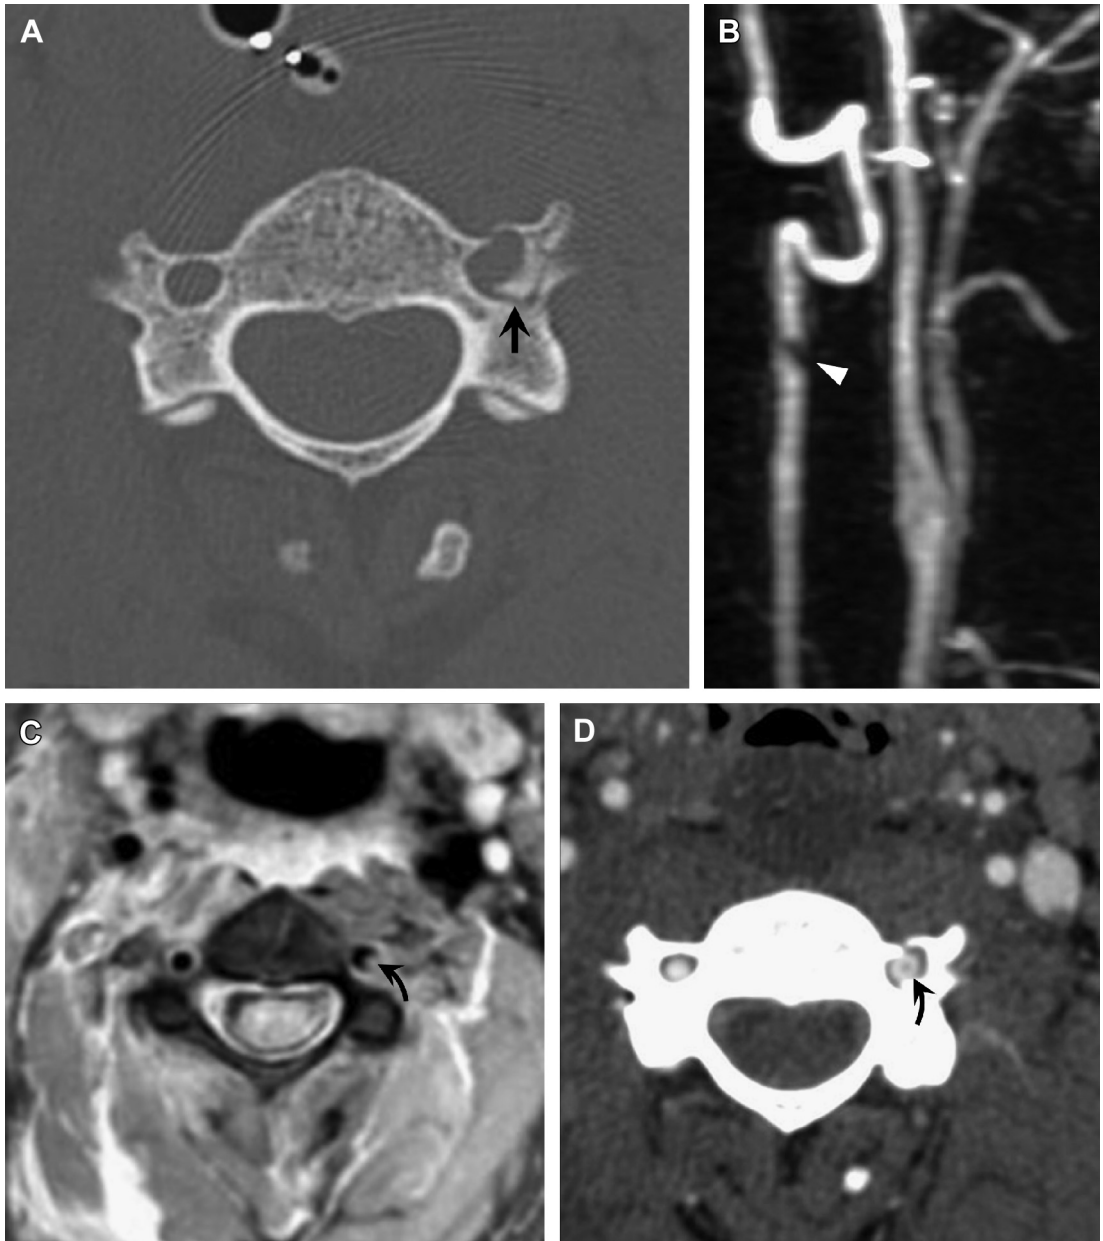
Displaced foramen transversarium fracture, vertebral artery dissection, and intraluminal thrombus. (A) Axial CT shows a comminuted foramen transversarium fracture with displaced bone fragments (*arrow*). (B) Contrast-enhanced MRA reveals a dissection flap (*arrowhead*) within the left vertebral artery lumen. (C) Contrast-enhanced MR and (D) CTA images confirm the presence of intraluminal thrombus (*curved arrow*) at the dissection site.
